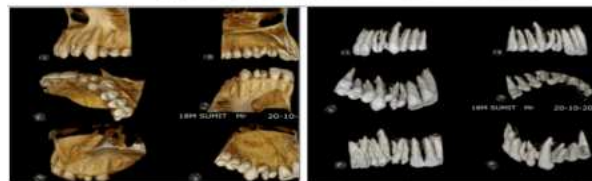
Pre-Operative Views (A-D), (E) IOPA, (F) CBCT
